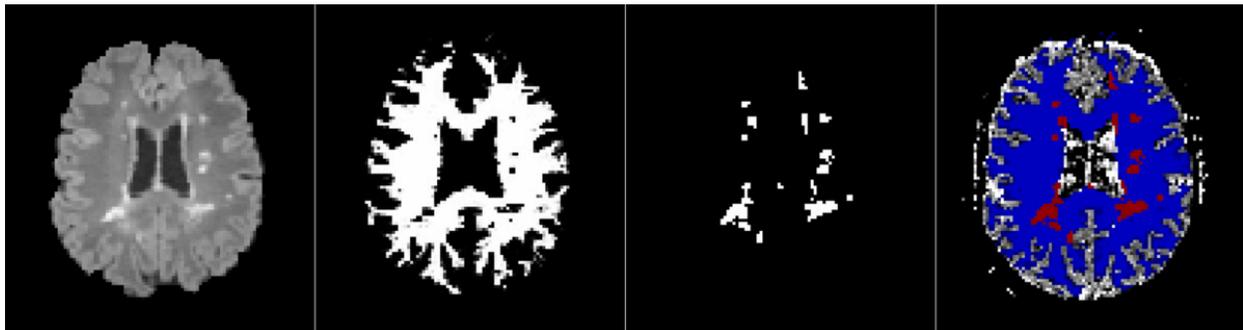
Fig. 2 Co-registered FLAIR series, WM and WML masks, and MTT map in a sample patient. FLAIR: fluid-attenuated inversion recovery; MTT: mean transit time; WM: white matter; WML: white matter lesions.
